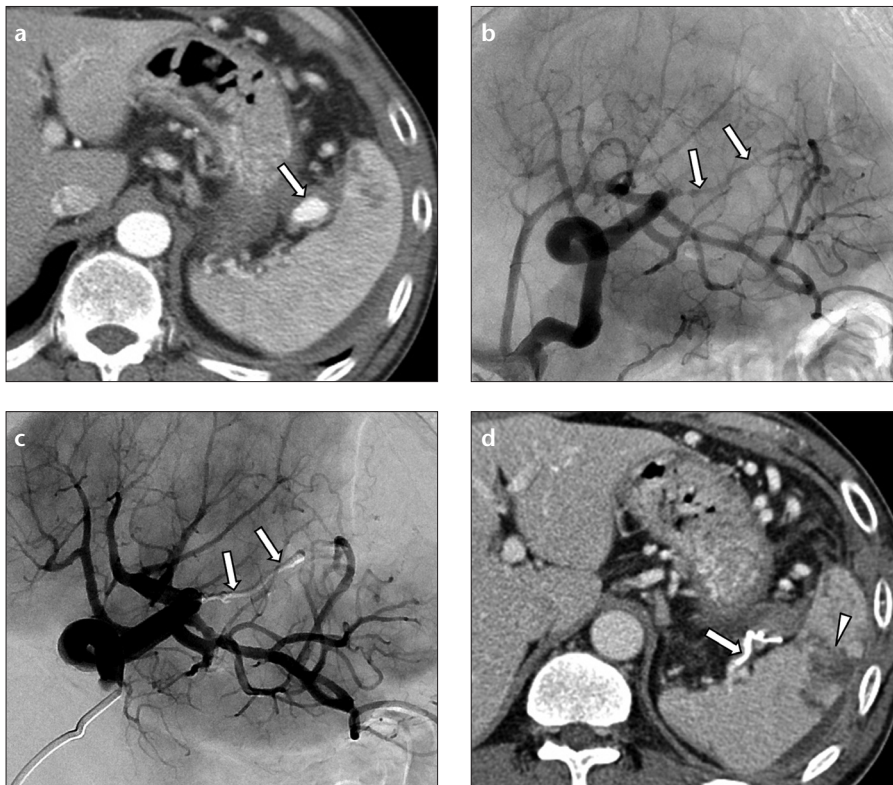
a-d. A 50-year-old male with chronic alcoholic pancreatitis was evaluated for exacerbated abdominal pain. Axial contrast-enhanced CT image (a) shows a pseudoaneurysm (arrow) situated near the splenic hilum. Splenic arteriogram (b) failed to demonstrate the pseudoaneurysm sac; however, luminal irregularity (arrows) is noted in one of the branches of the splenic artery. Completion splenic arteriogram (c) shows embolization of the irregular branch artery using N-butyl cyanoacrylate (arrows). Follow-up axial contrast-enhanced CT image (d) shows thrombosis of the pseudoaneurysm sac. Although localized splenic infarction (arrowhead) was seen on CT, the patient was asymptomatic. Note the hyperattenuating embolic material (arrow) within the splenic artery near the splenic hilum.
